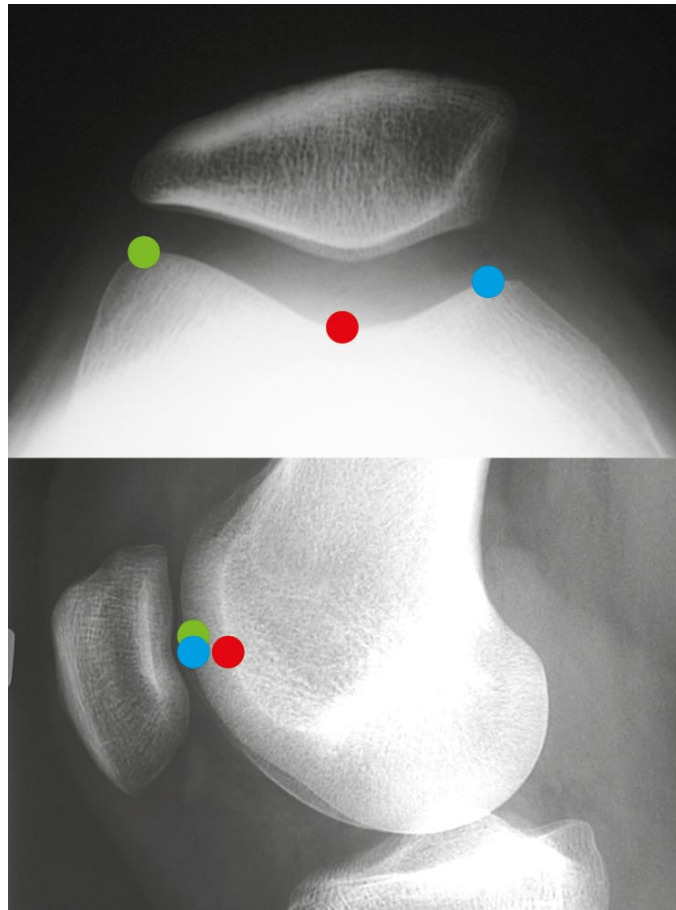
Lateral radiograph
